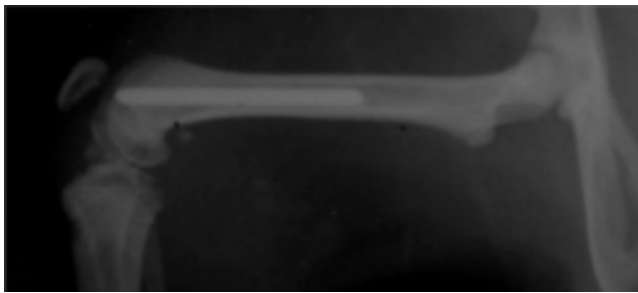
X-ray of a femur with a Ti6Al4V needle implanted inside it.
